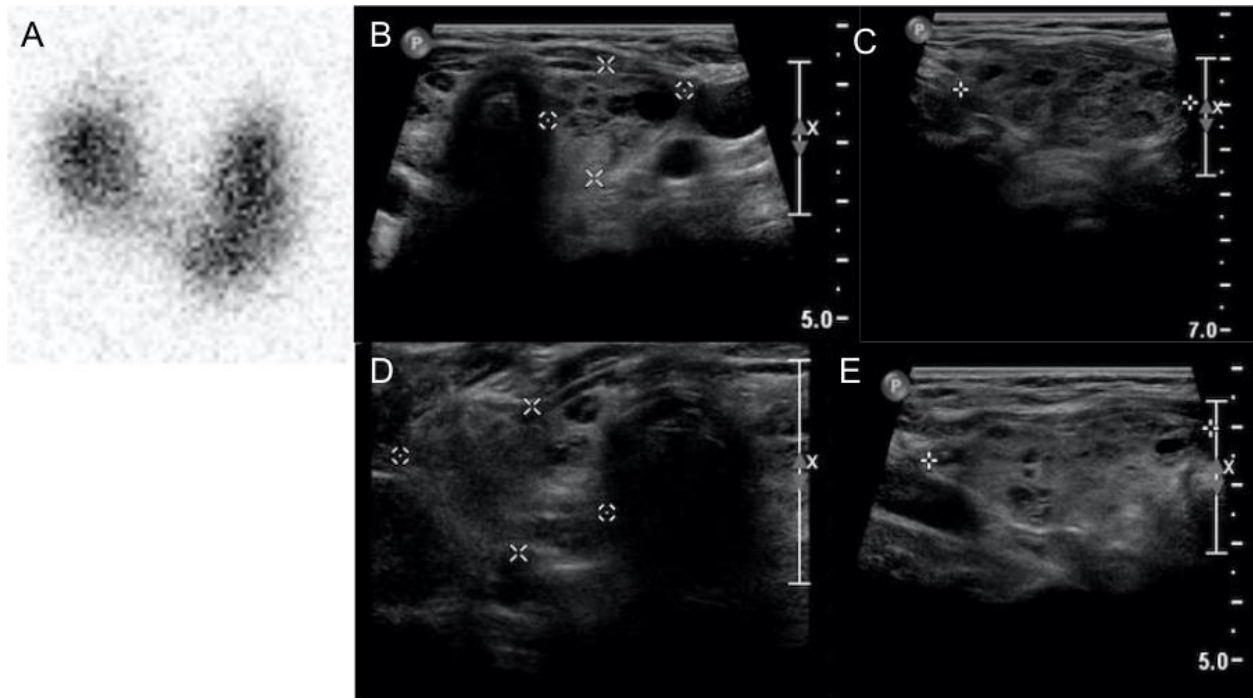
Planar ^{123}I scintigraphy imaging (NM) and Ultrasonography (US) of a patient with Graves' disease.
